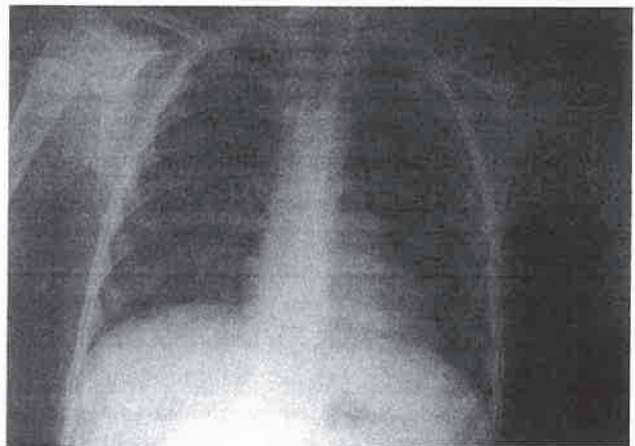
Plain x-ray of the chest on the admission with no pathologic scene
